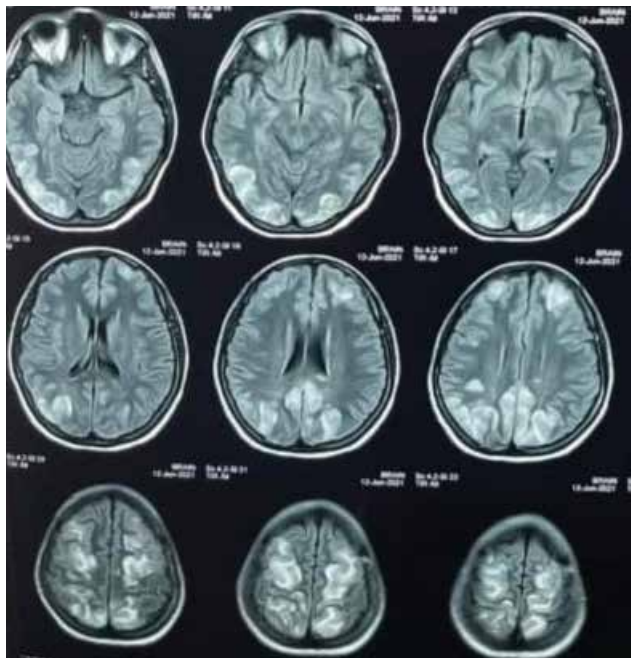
MRI of brain showing bilateral symmetrical cortical and sub-cortical hyper intense signal changes in parieto- occipital regions.
